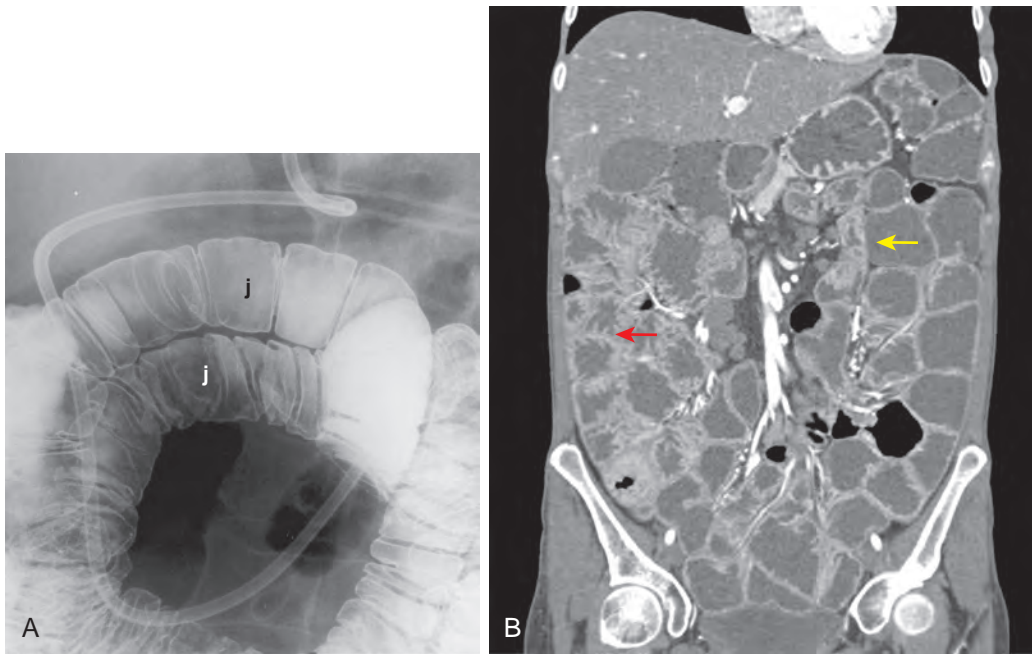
Celiac disease. A. This spot radiograph from enteroclysis shows a paucity of folds (two to three folds/inch) in two loops of jejunum (j). However, the folds are of normal thickness. B. Coronal reformatted CT scan in another patient show markedly increased small bowel secretions. Note that the ileal folds (red arrow) are larger than jejunal folds (yellow arrow).
